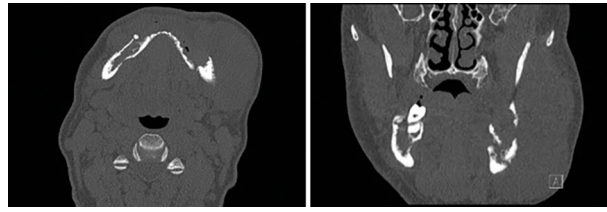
Coronal and axial CT views demonstrating the extent of swelling and bony destruction of the left mandible
